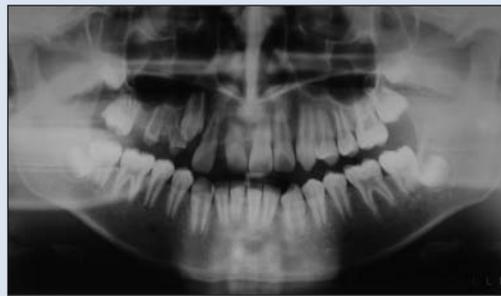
Orthopantomogram taken at age 11.5 years, showing very thin radicular dentin in teeth 11, 14 and 15. The roots of teeth 12 and 13 appear normal.
